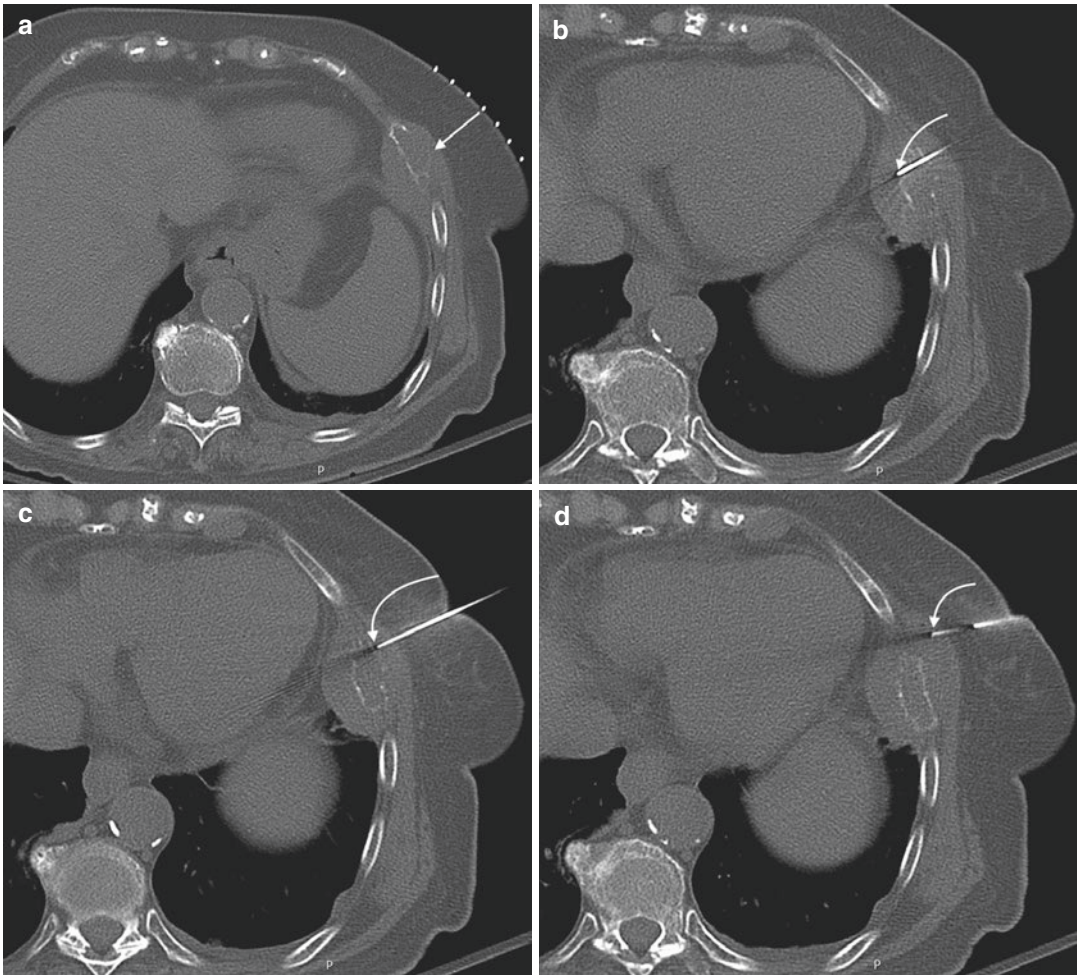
A 76-year-old female with a history of adenoid cystic carcinoma of the submandibular gland; chest CT shows anterior sixth rib mass. Axial CT image (a) from a biopsy procedure shows a skin grid in place and a large expansile anterior rib lesion (arrow) with cortical expansion and destruction and a prominent extraosseous soft tissue component. Axial CT image (b) shows tip of 19
